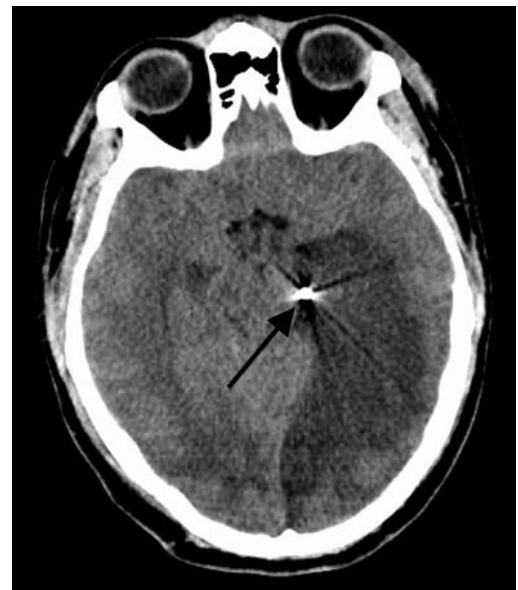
Non-contrast CT of the head shows interval displacement of a radiopaque foreign body to the left PCA (arrow) with loss of gray white matter differentiation consistent with left PCA territorial infarction.
